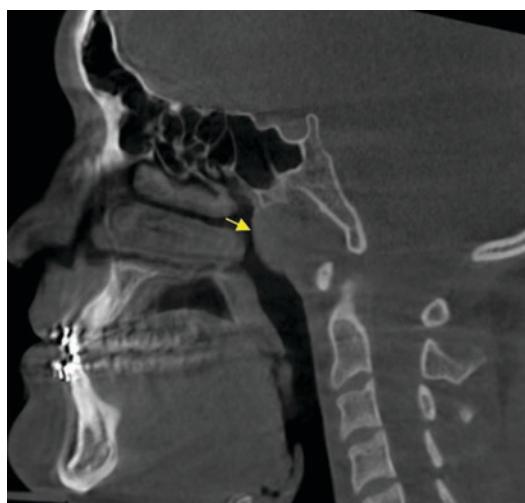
Sagittal CBCT view shows the narrowing of airway due to enlarged adenoids (yellow arrow)
